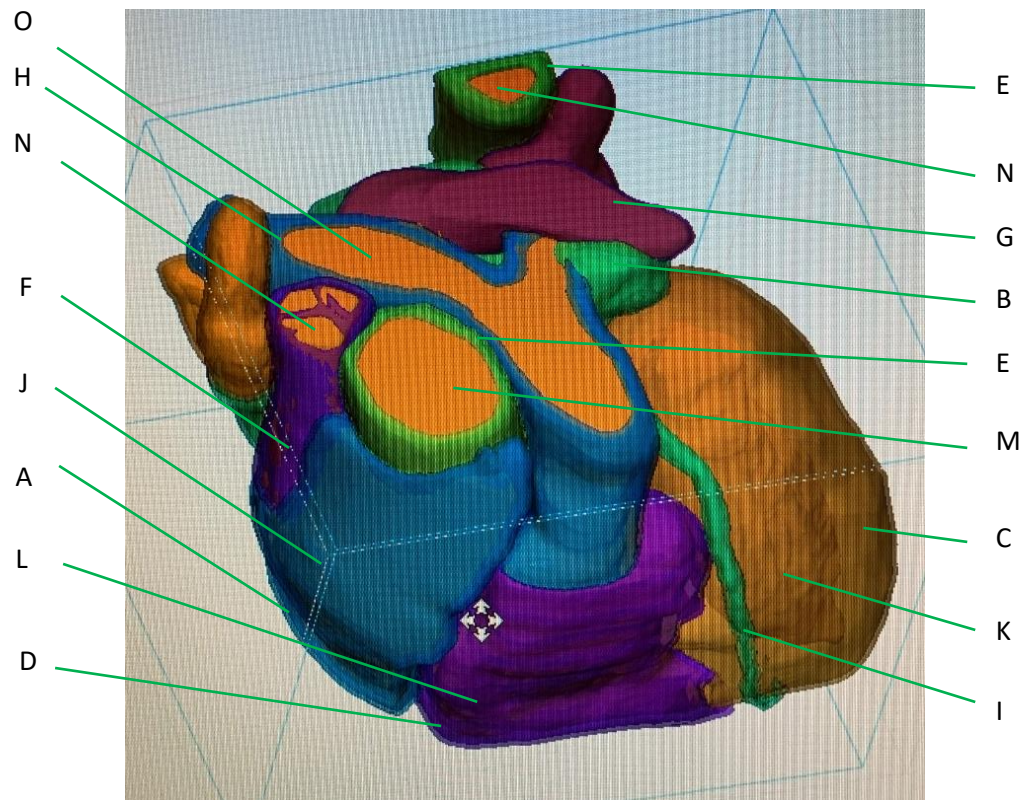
3D segmented model of anatomical heart on contrast-enhanced CT, superior-anterior-right oblique view. Labelled (where feature is visible) according to Table 3.3
